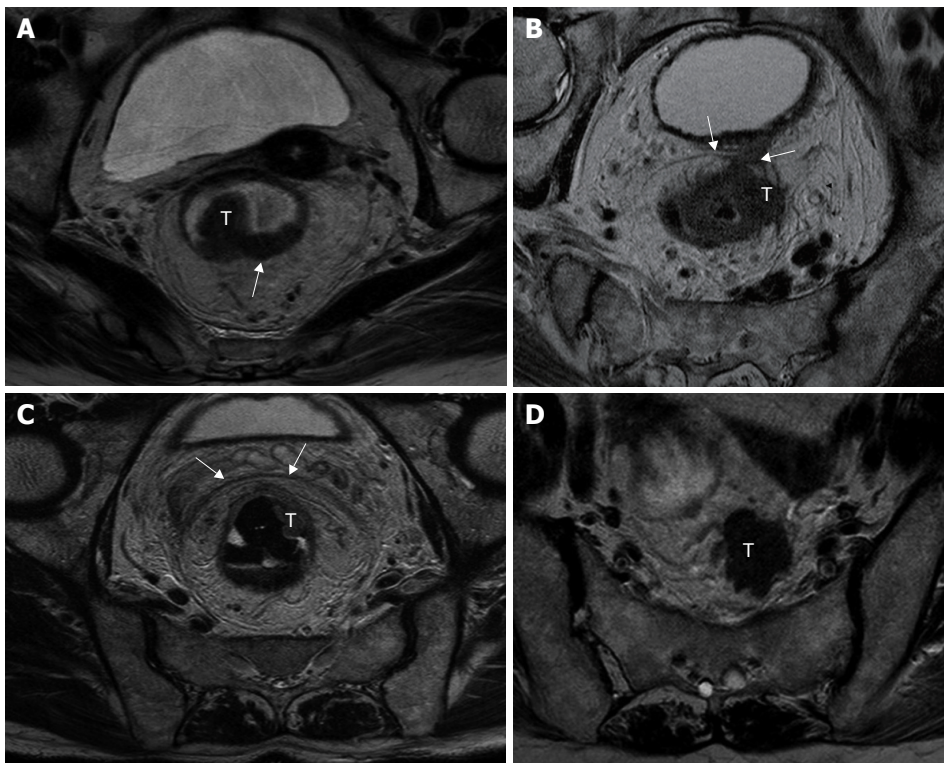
A: T3-stage rectal cancer without mesorectal fascia involvement in a 57-year-old female patient. Axial T₂W-TSE MR image (3000/98) manifested bulky tumor with broad-based nodular (T) with clear margin (white arrows); B: T3-stage rectal cancer with involved mesorectal fascia in a 79-year-old male patient. Axial T₂W-TSE MR image (3000/98) showed tumor (T) extending to mesorectal fascia (white arrows); C: T3-stage rectal cancer with involved mesorectal fascia in a 65-year-old male patient. Axial T₂W-TSE MR image (3000/98) showed heterogeneous strands are noted in the perirectal fat tissues with the thickened mesorectal fascia; D: T3-stage rectal cancer with extramural deposits in a 62-year-old female patient. Axial T₂W-TSE MR image (3000/98) showed extramural deposits (T) in the perirectal space with irregular shape.
